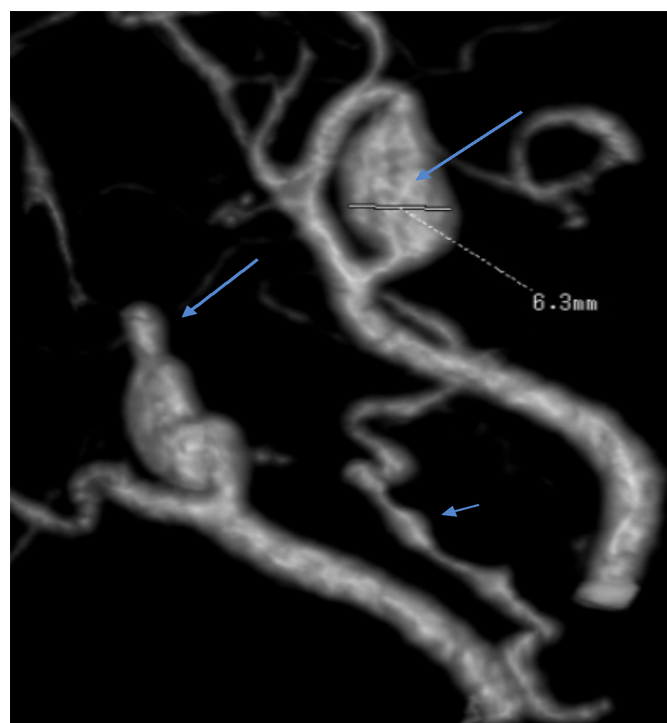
CT of the brain showing bilateral carotid artery aneurysms (blue arrows).
